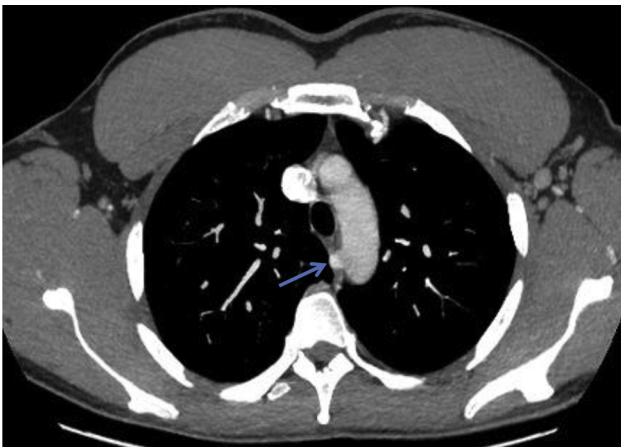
Case 1: Axial MIP image of the CT scan of the chest showing aneurysmal origin of the aberrant right vertebral artery (blue arrow) reminiscent of a Kommerell diverticulum.
